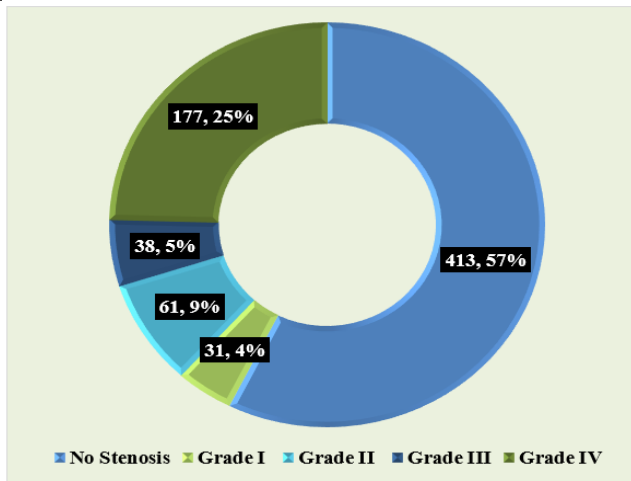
Lower limb arterial Grade of Stenosis in color doppler
